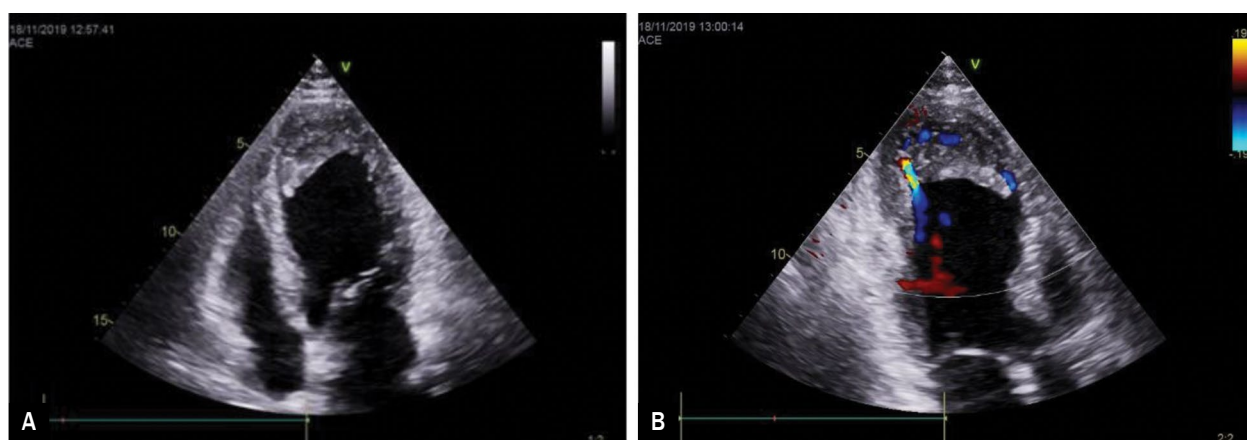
Transthoracic echocardiography: thrombus in the left ventricular apex in four-chamber apical view and three-chamber apical view
